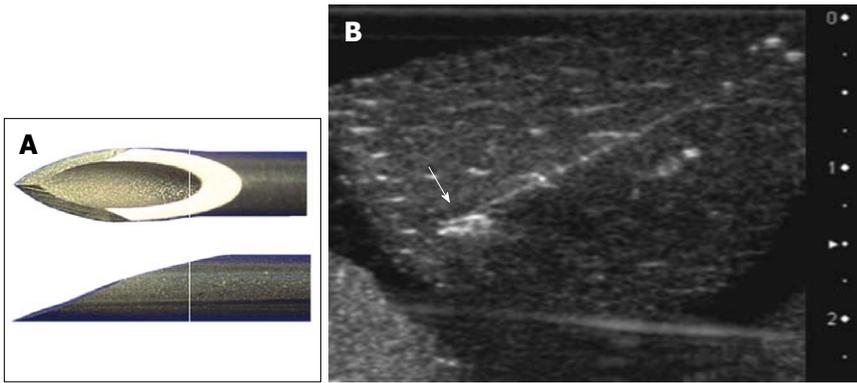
Commercially available vascular needle (control). A: Needle tip; B: Corresponding ultrasound image. The arrow indicates the needle tip.
